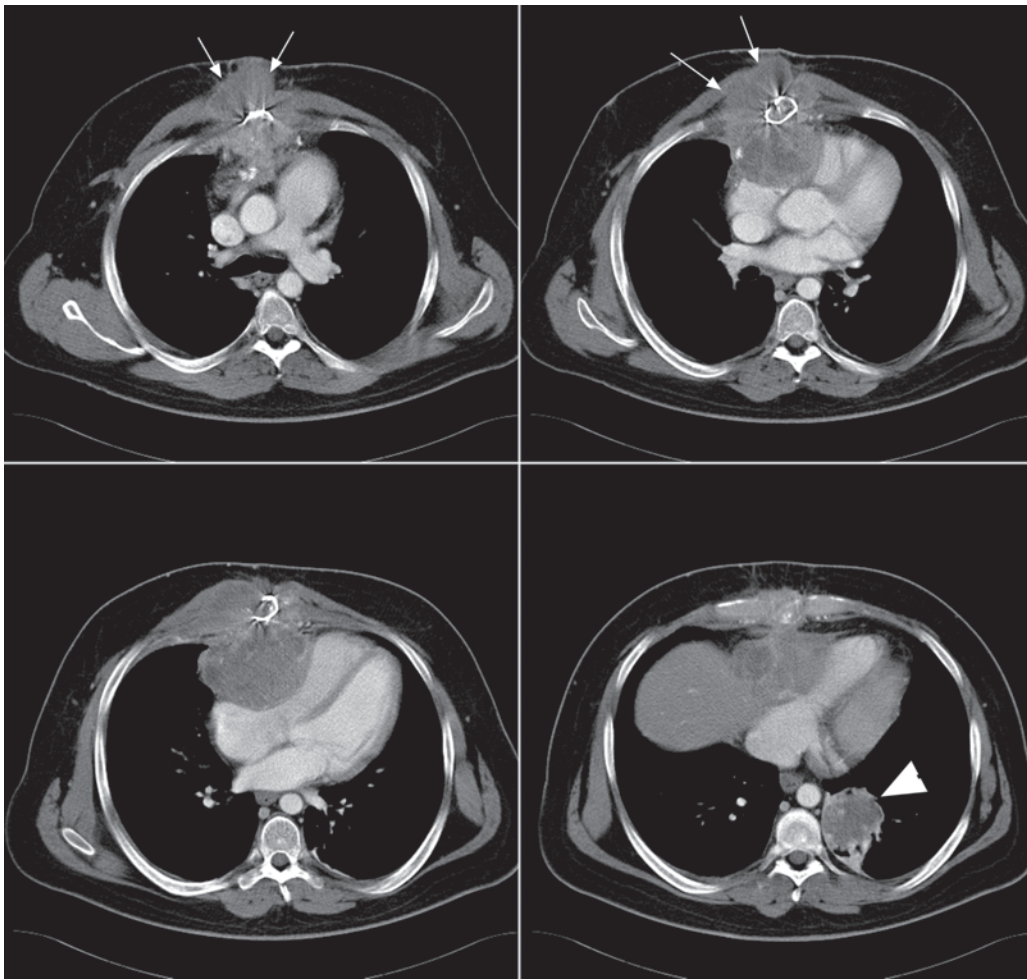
A set of axial multidetector-row CT images of a malignant hemangiopericytoma involving the right coronary artery and the chest wall (arrows). The tumor encases the right atrium and ventricle. Within the left lower lobe of the lungs, metastatic disease is shown.
